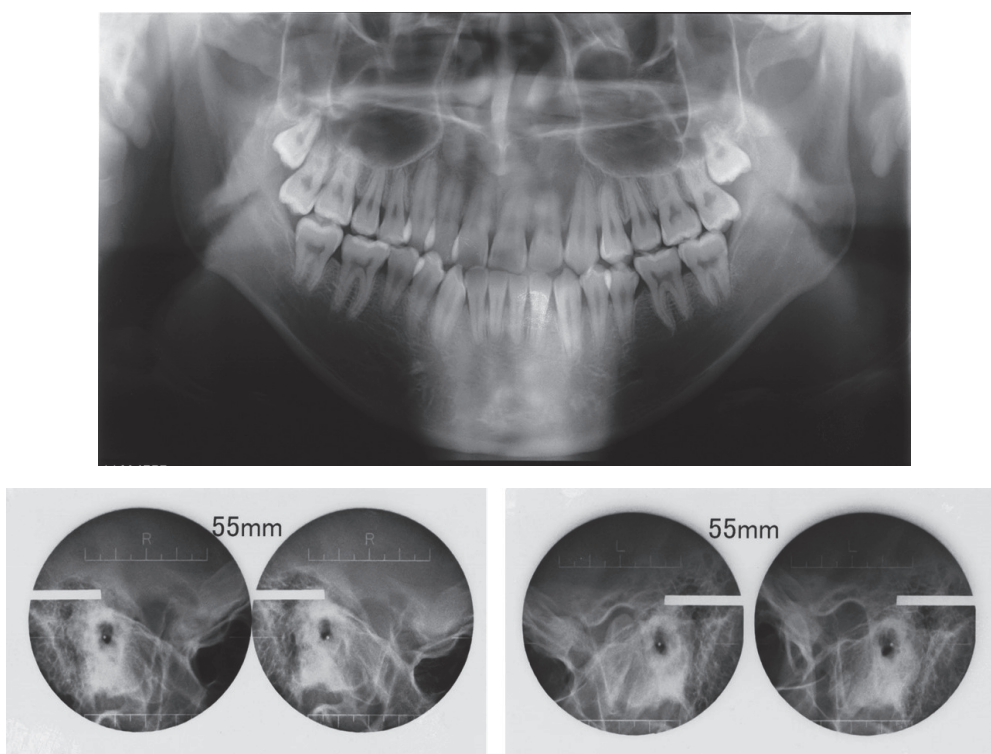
Orthopantomogram and Schüller projection
